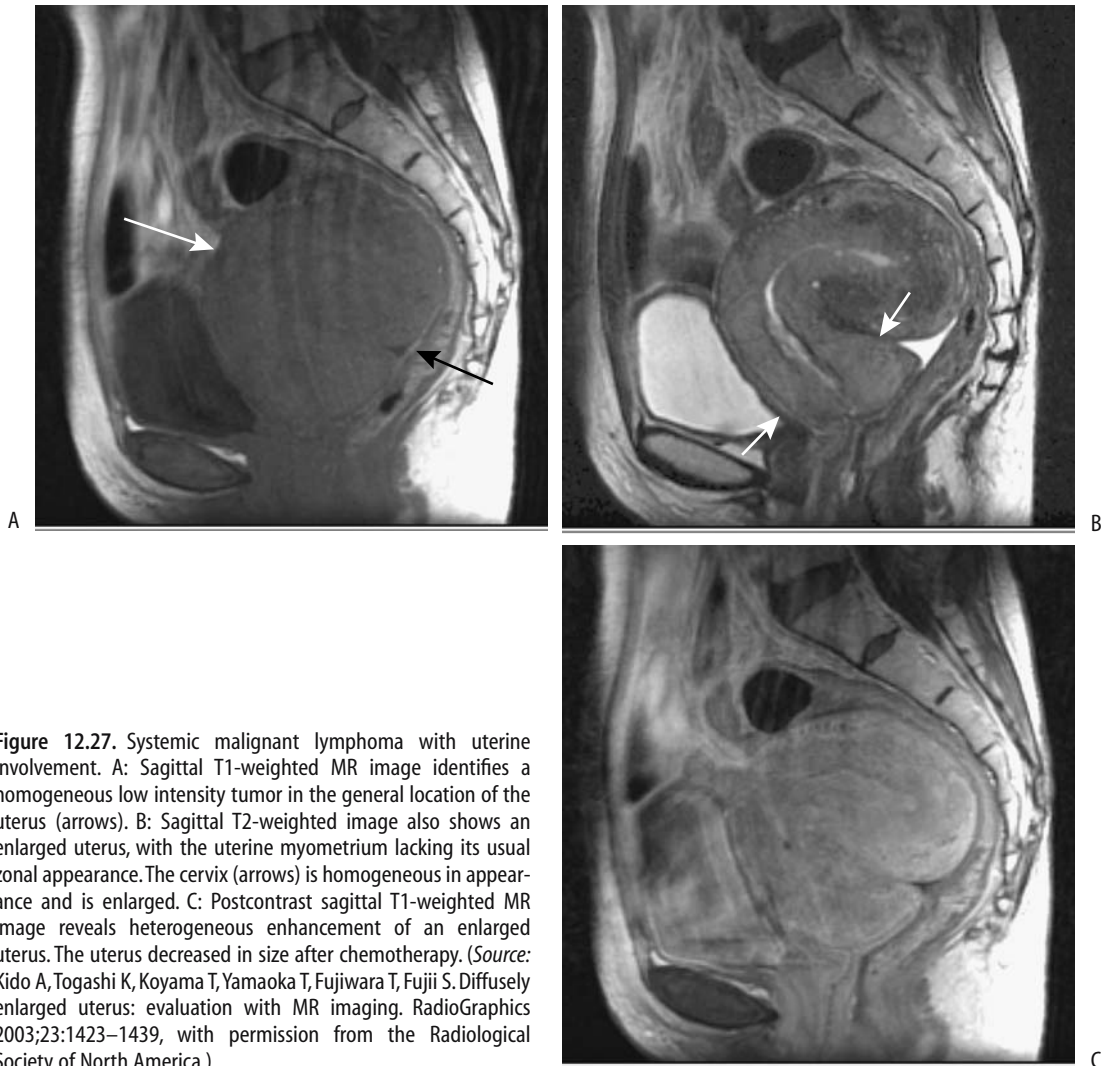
Systemic malignant lymphoma with uterine involvement. A: Sagittal T1-weighted MR image identifies a homogeneous low intensity tumor in the general location of the uterus (arrows). B: Sagittal T2-weighted image also shows an enlarged uterus, with the uterine myometrium lacking its usual zonal appearance. The cervix (arrows) is homogeneous in appearance and is enlarged. C: Postcontrast sagittal T1-weighted MR image reveals heterogeneous enhancement of an enlarged uterus. The uterus decreased in size after chemotherapy. (Source: Kido A, Togashi K, Koyama T, Yamaoka T, Fujiwara T, Fujii S. Diffusely enlarged uterus: evaluation with MR imaging. *RadioGraphics* 2003;23:1423–1439, with permission from the Radiological Society of North America.)
